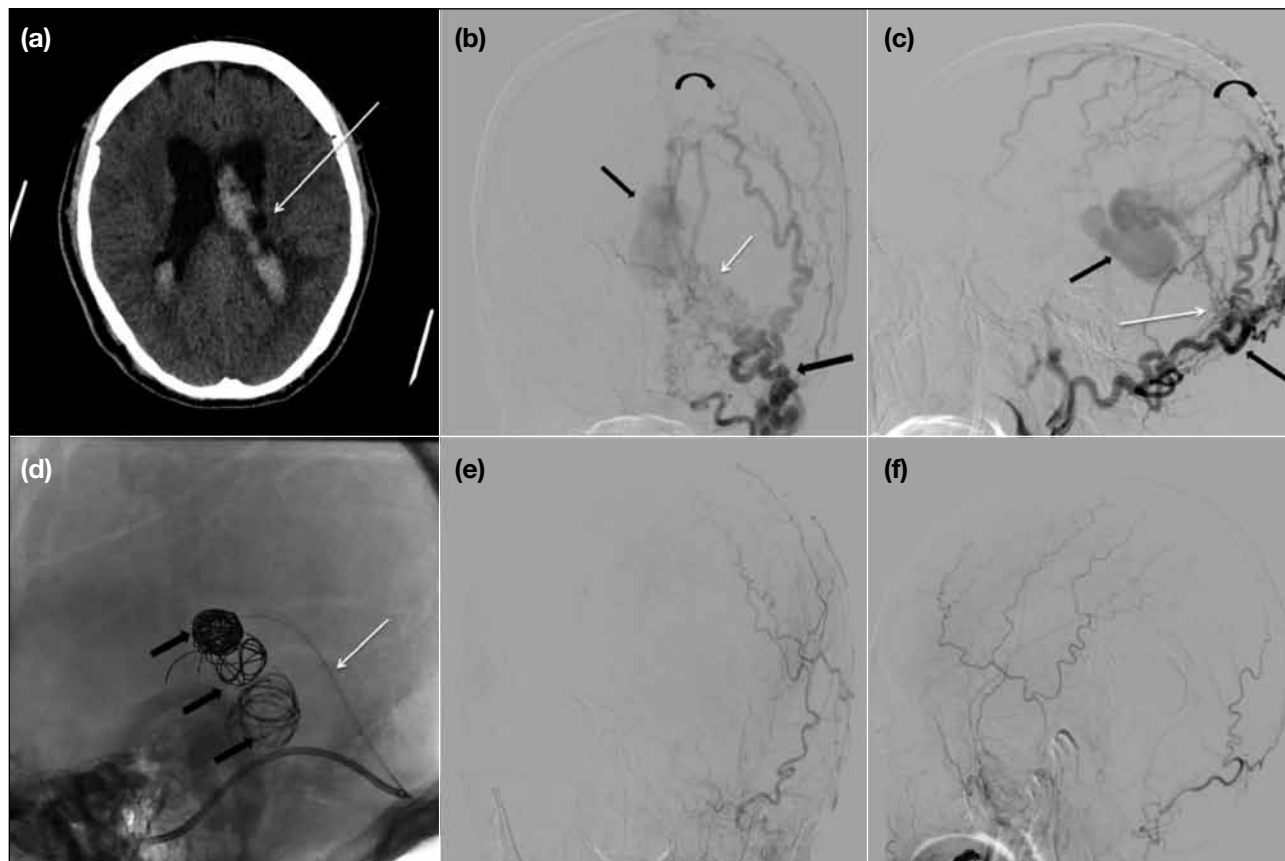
Case 3. Patient presented with headache and altered mental status. (a) Computed tomography of the brain showing intraventricular haemorrhage (arrow). Cranial AP (b) and lateral (c) views of left external carotid digital subtraction angiographies showing an extensive dural arteriovenous fistulas (white arrows) at junction of vein of Galen and straight sinus, with venous varices (straight black arrows) at vein of Galen. Cortical venous reflux (curved arrows) is identified. (d) Intra-operative image showing a Marathon microcatheter (white arrow) inserted through the Benchmark™ 071 guiding catheter. The pouch-like venous outflow is being embolised with multiple coils (black arrows), followed by Onyx 18. Cranial AP (e) and lateral (f) views of left external carotid digital subtraction angiographies performed 6 months after embolisation, showing complete occlusion of the dural arteriovenous fistulas, and no cortical venous reflux.
